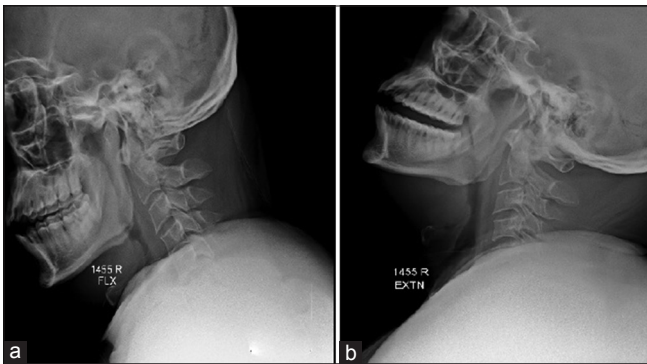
Preoperative dynamic X-ray (a) flexion (b) extension. No evidence of instability
